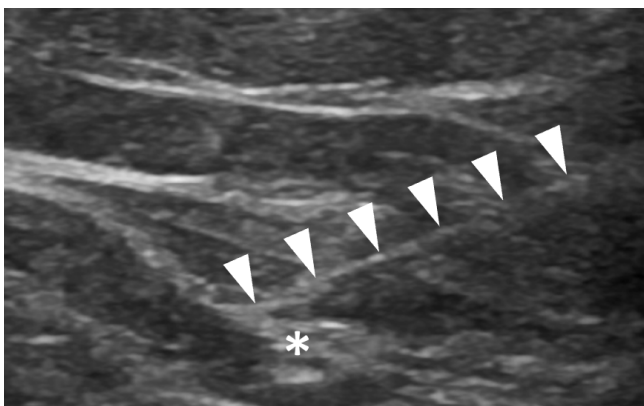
Ultrasound-guided perineural injection of the anterolateral femoral cutaneous nerve. Arrowheads indicate the in-plane trajectory of the advancing needle, directed toward the perineural fat plane adjacent to the nerve (asterisk). Proper needle positioning allows safe deposition of the injectate around the nerve while avoiding nearby vascular and fascial structures
